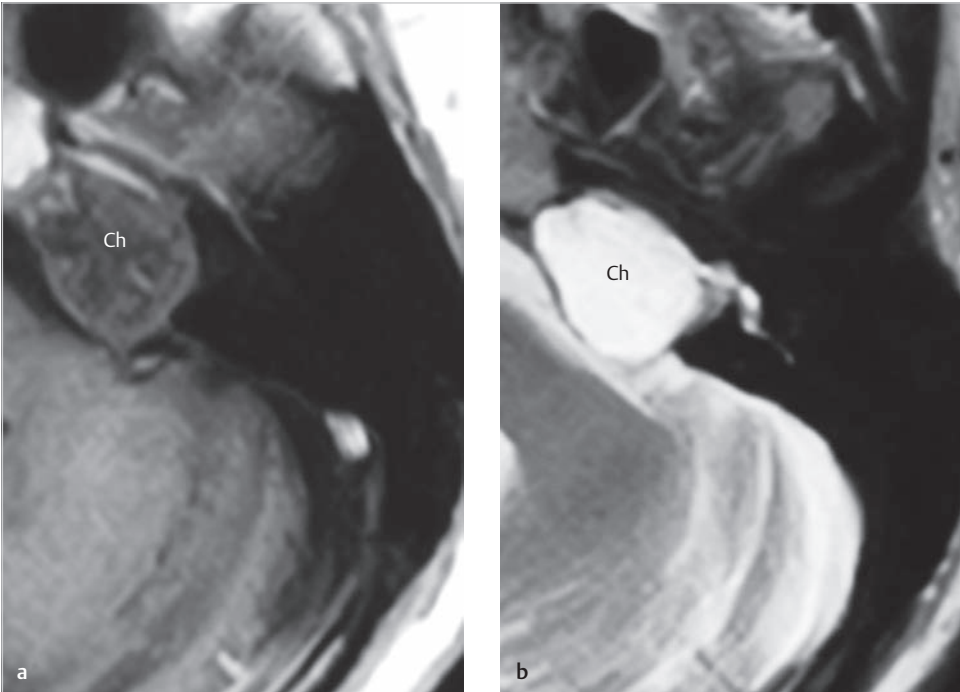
The lesion shows low signal intensity in T1-weighted image (a), and very high intensity in T2 (b), corresponding to petrous bone cholesteatoma. Ch, cholesteatoma.
